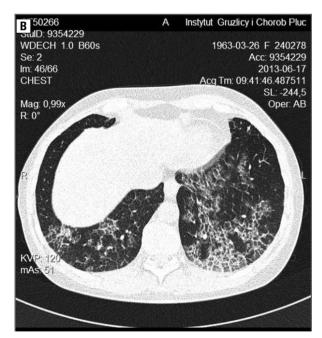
HRCT scan before (A) and after (B) whole lung lavage — visible partial regression of infiltrates
